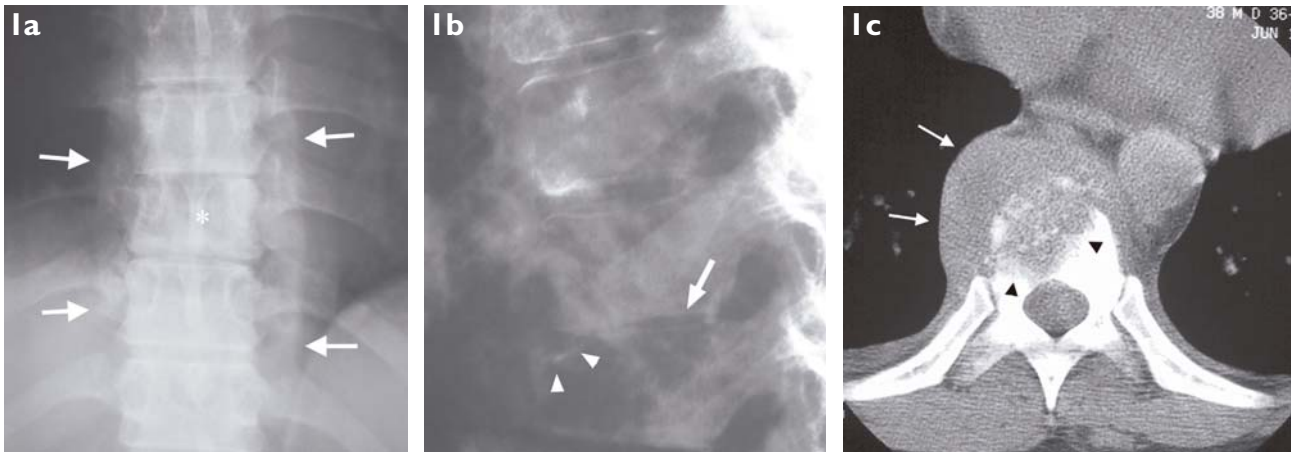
TB spondylodiscitis in a 38-year-old man. a) AP radiograph of the thoracolumbar spine shows partial loss of height of T9 vertebral body (*). Loss of T8/9 disc and end-plate irregularity are seen. Paravertebral masses (arrows) are noted. b) Lateral radiograph shows anterior wedging and erosion of antero-superior subchondral region of T9 vertebral body (arrowheads). Narrowing of the T8/9 intervertebral disc space is present (arrow). c) Axial CT image of T9 vertebral body shows vertebral body destruction (arrowheads), with associated adjacent soft tissue mass (arrows).
